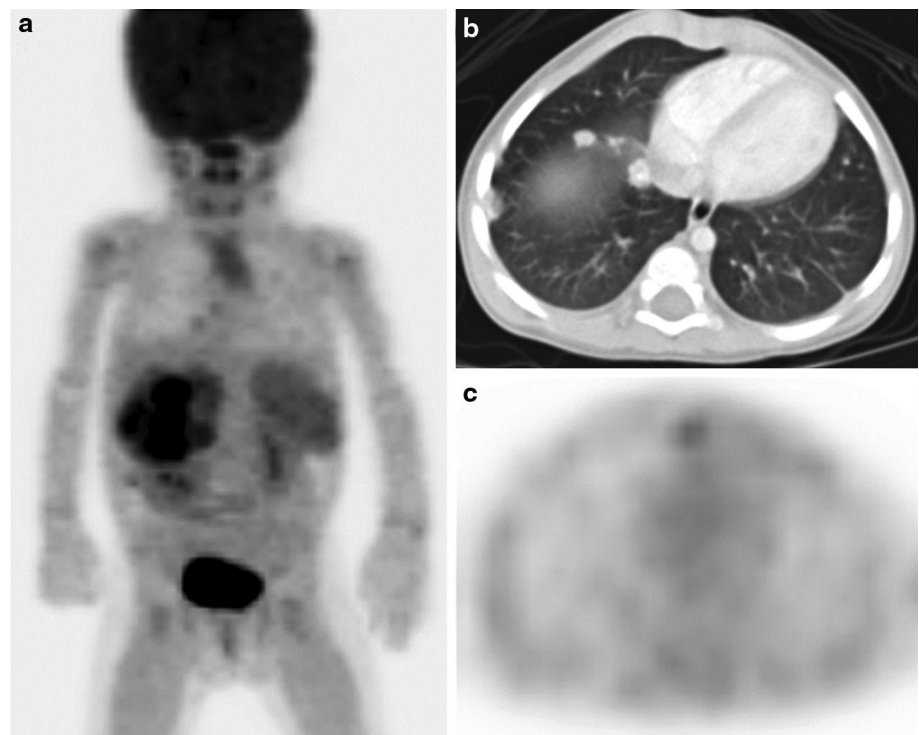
Image findings of a 14-month-old girl with stage 4 neuroblastoma. a ^{18}F -FDG PET anterior maximum-intensity projection image demonstrates intense uptake at *right upper* quadrant of abdomen. b Multiple nodules in the *right lower* lung base are seen
